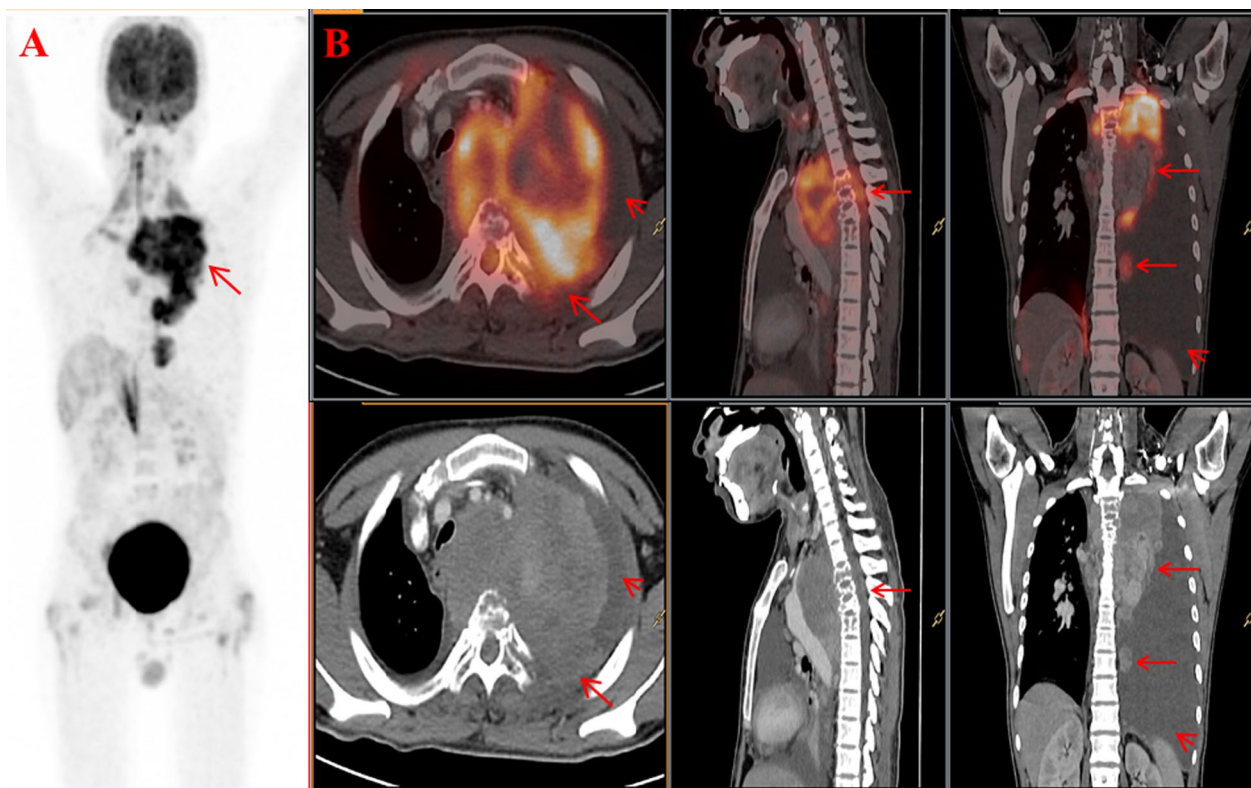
A 20-year-old male, presented with pain in mid-back for one month, weakness of sudden onset in bilateral lower limbs for 1 week which progressed to a complete loss of function of both legs, incomplete voiding of urine and constipation for the past 2 days. Maximum intensity projection (MIP) image of ^{18}F FDG PET scan A showing a large area of tracer uptake in the left hemithorax and midline region. Axial, sagittal and coronal PET/CT and corresponding CT images B showing metabolically active large posterior mediastinal mass with intracanalicular extension (in sagittal images) and left mediastinal pleural deposits (in coronal images) with left pleural effusion (arrow head)
